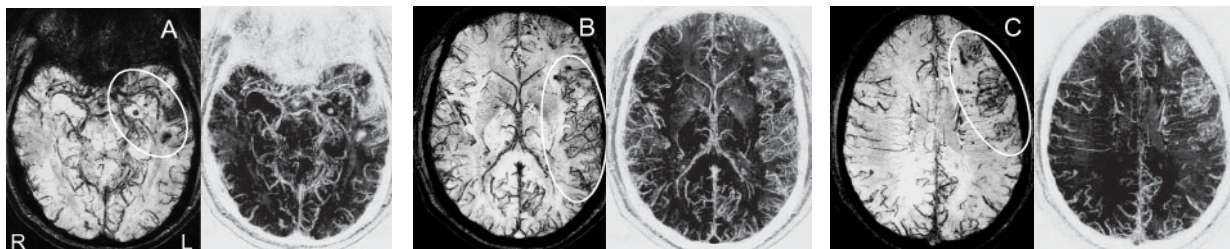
MinIP Projections = 4.4 mm slabs. Images are oriented in standard radiographic presentation. Normal and reverse contrast shown at the locations mentioned above.
